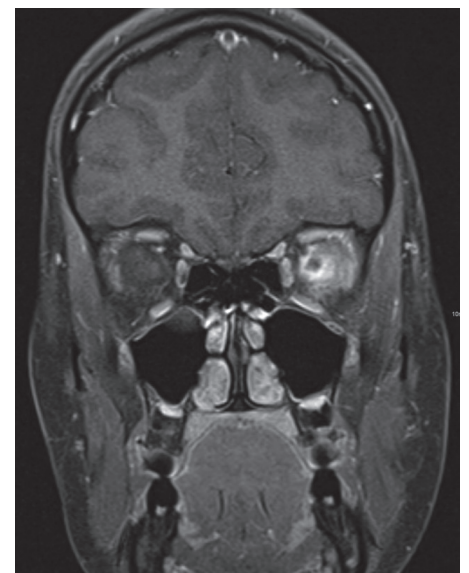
MRI orbital. Coronal T1-weighted image after contrast with fat saturation shows left enhancement retrobulbar and perineural involving the muscles.
